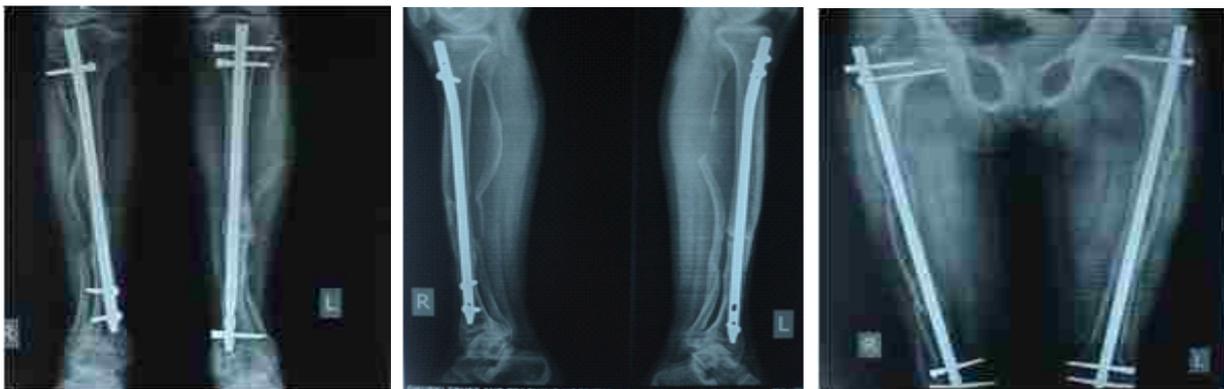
a,b,c:Post opp x-rays after 6 months.
